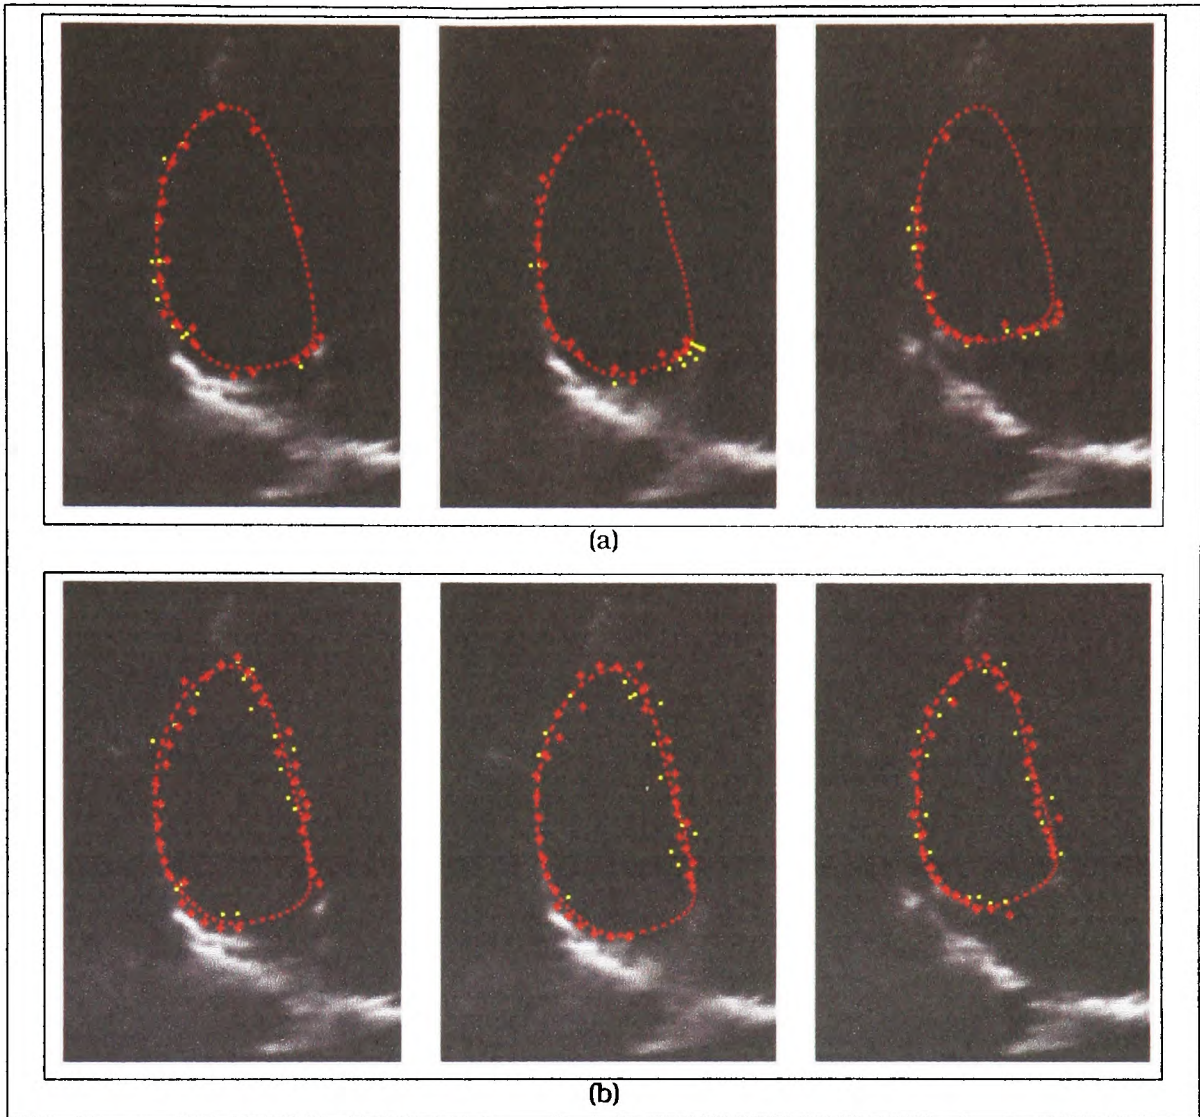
Feature detection. Traditional computer vision edge detection has used intensity based feature detection. This fails in the case of echocardiographic data. Image intensities vary both by the position along the left ventricular wall, and the time in the cardiac cycle, as well as the gains used by the clinicians when recording the images. The result is that it is difficult to choose a global (and regional) intensity based feature gradient threshold. The contour is shown as a red dashed curve. For each normal, features above the noise threshold are shown as yellow dots with the strongest feature shown as a red cross. (a) Intensity based image feature detection with a gradient threshold that is the same for each normal. (b) Intensity-invariant phase based image feature detection with a local phase threshold that is the same for each normal.
